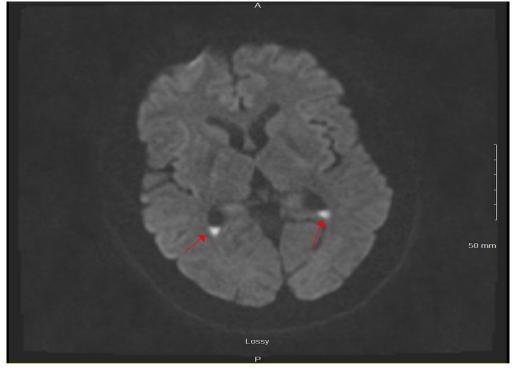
Brain MRI: Magnetic resonance image of the brain showing bilateral 6 mm x 4 mm collections layering in the posterior horns of the lateral ventricles (red arrows). The differential diagnosis includes ventriculitis versus mild subarachnoid hemorrhage.
